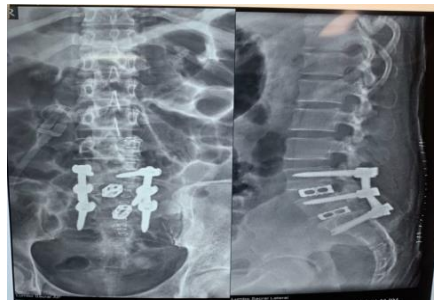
5B, and 5C POST OPERATIVE XRAY AT IMMEDIATE , 6MONTHS FOLLOWUP AND AFTER 1 YEAR FOLLOWUP SHOWING CAGE SUBSIDENCE
